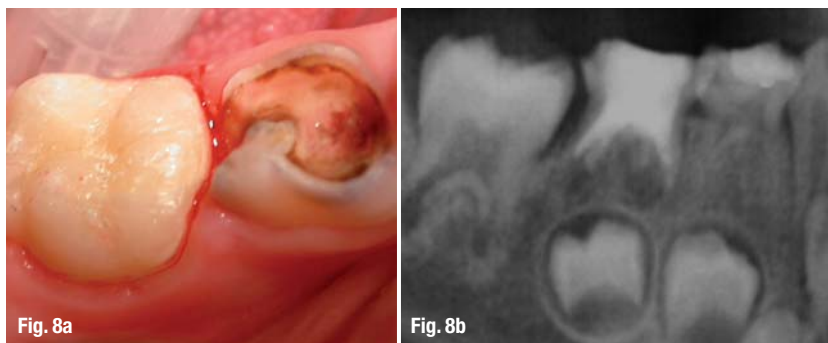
a & b _Final outcome: colour and morphology are restored by the anatomical layering technique. Post-treatment X-ray control (b).
